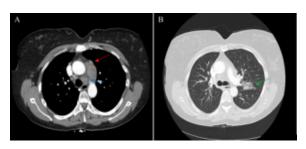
A. Transverse CT of chest showing preaortic lymph node (red arrow) and 4.8 x 2.6 cm mediastinal lymphadenopathy (blue arrow) including in the AP window node. No hilar or axillary adenopathy. B. Transverse CT within lung window of chest showing a ground glass consolidation 2.9 x 2.1 cm lesion in left upper lobe (green arrow).
